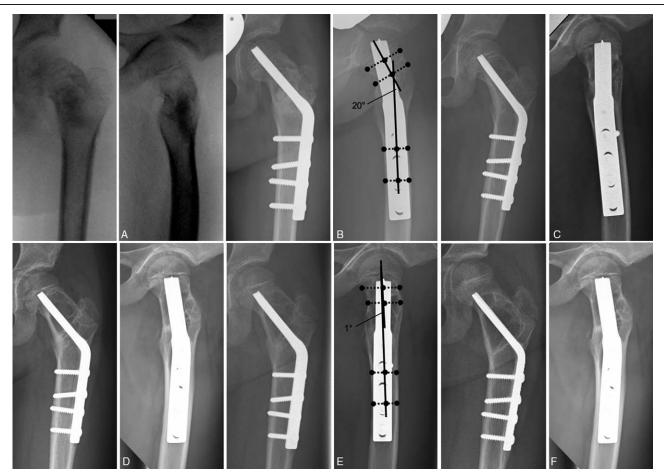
Imaging of a 5-year-old male patient with SBC of the proximal femur. (A) Anteroposterior and lateral radiographs showing the non-fractured SBC. (B) Anteroposterior and lateral radiographs 1 year after intralesional curettage of the SBC, defect reconstruction with bone supplement and fixation by non-locking reconstruction plate. (C) Anteroposterior and lateral radiographs 1 year after operation with initial signs of local recurrence of the former curetted SBC. (D) Anteroposterior and lateral radiographs 5 years after operation showing further progression of the SBC.
